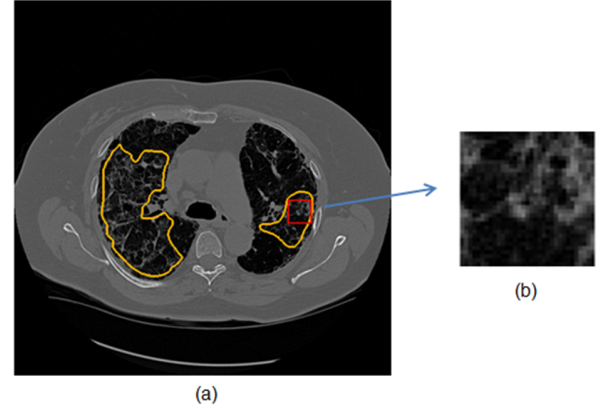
A sample lung HRCT image slice shown in (a), in which the orange contours indicate two AROIs, and the red box highlights an image patch that is shown in (b).
